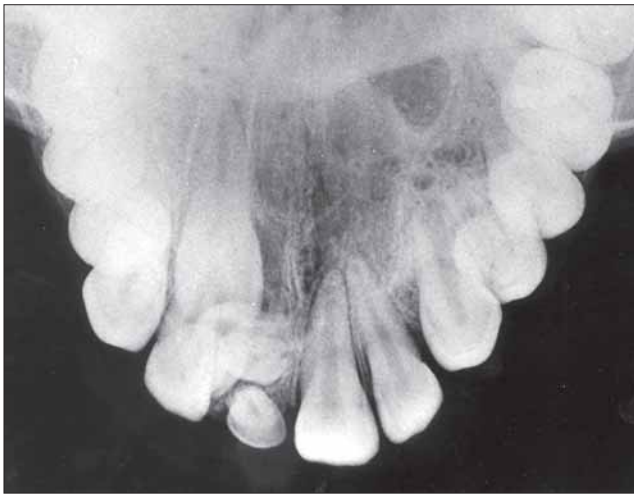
Case 3. Occlusal radiograph showing small mineralized structures in the interior of the lesion.
